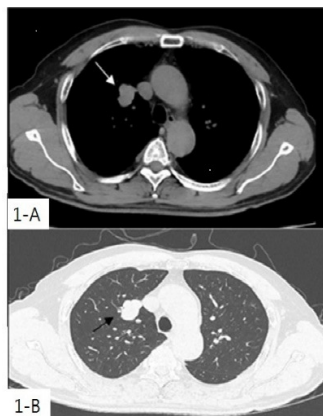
chest computed tomography imaging (A : soft tissue Window setting , B : lung window setting )
